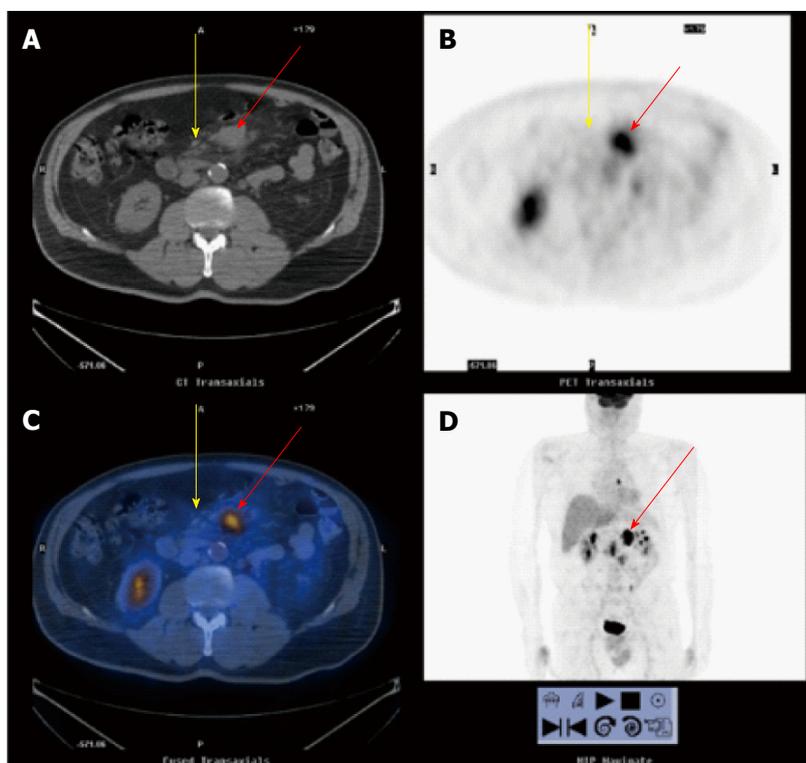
Mesenteric panniculitis in a patient with non-Hodgkin lymphoma (same patient as Figure 2). Positron emission tomography-computed tomography (PET-CT) scan. CT image (A), PET image (B), fused PET-CT image (C), and whole body PET image (D) shows abnormal fludeoxyglucose uptake in the mesenteric lymph nodes containing tumor (red arrows) but not in the portion of mesentery involved by mesenteric panniculitis (yellow arrows).
